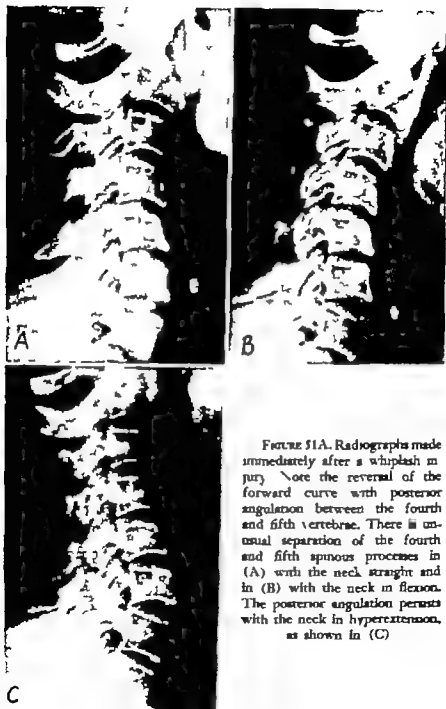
Radiographs made immediately after a whiplash injury. Note the reversal of the forward curve with posterior angulation between the fourth and fifth vertebrae. There is unusual separation of the fourth and fifth spinous processes in (A) with the neck straight and in (B) with the neck in flexion. The posterior angulation persists with the neck in hyperextension, as shown in (C).
